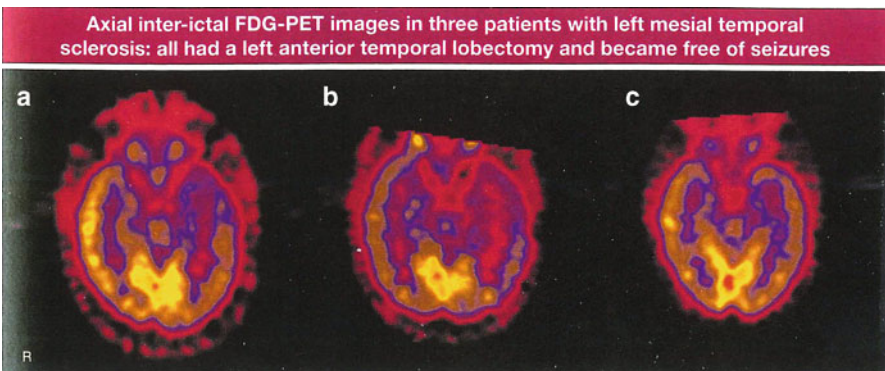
(a) Unilateral glucose hypometabolism shown by FDG uptake in mesial temporal lobe and temporal neocortex in the left hemisphere, (b) bilateral glucose hypometabolism in both temporal areas, and (c) equivocal glucose metabolism without laterality. With kind permission of Springer Science+Business Media: *Epileptic Syndromes and their Treatment*, 2010, p. 167, Panaylotopoulos, C., Fig. 6.12
